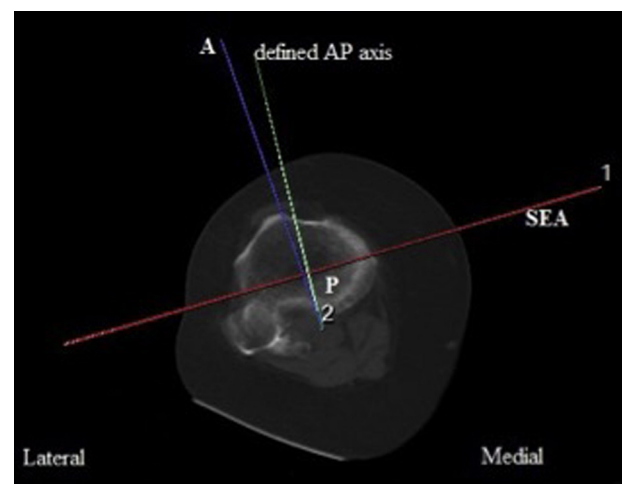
Axial CT image at the level of the patellar tendon attachment, in which angle A is the angle between the AP axis and the line connecting the medial 1/3rd of the patellar tendon to the PCL.
